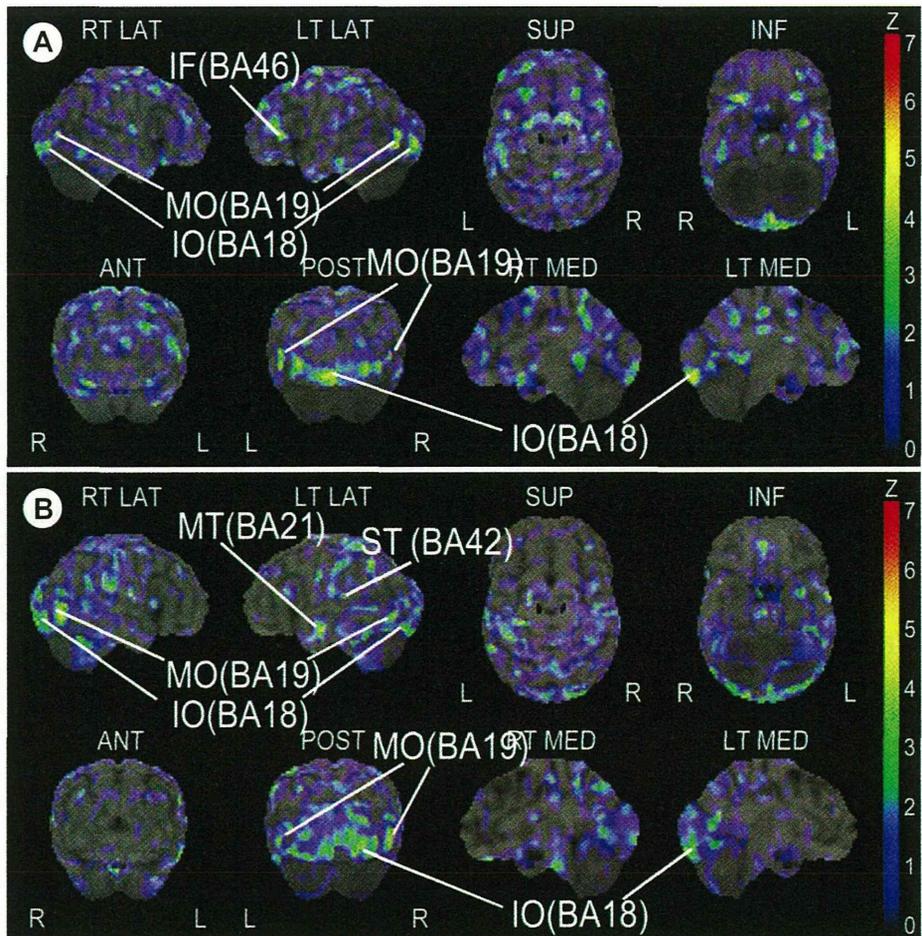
Decreased ^{18}F -fluorodeoxyglucose uptake areas examined by positron emission tomography-computed tomography. A) Subject 1. B) Subject 2. BA — Brodmann area; IF — inferior frontal gyrus; MO — middle occipital gyrus; IO — inferior occipital gyrus; MT — middle temporal gyrus; ST — superior temporal gyrus.
